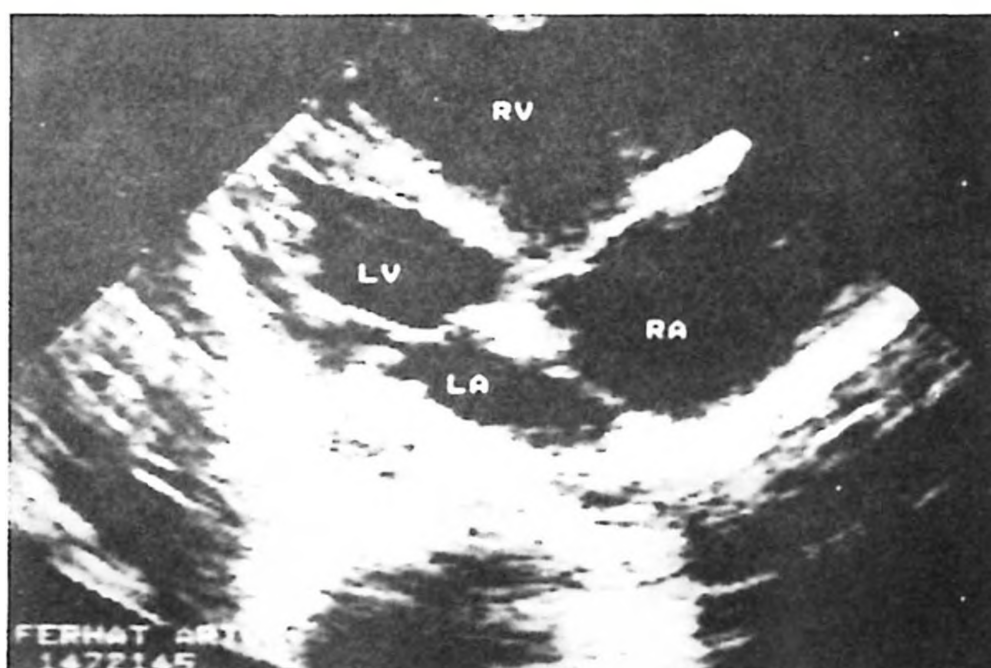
Apical four-chamber view.
